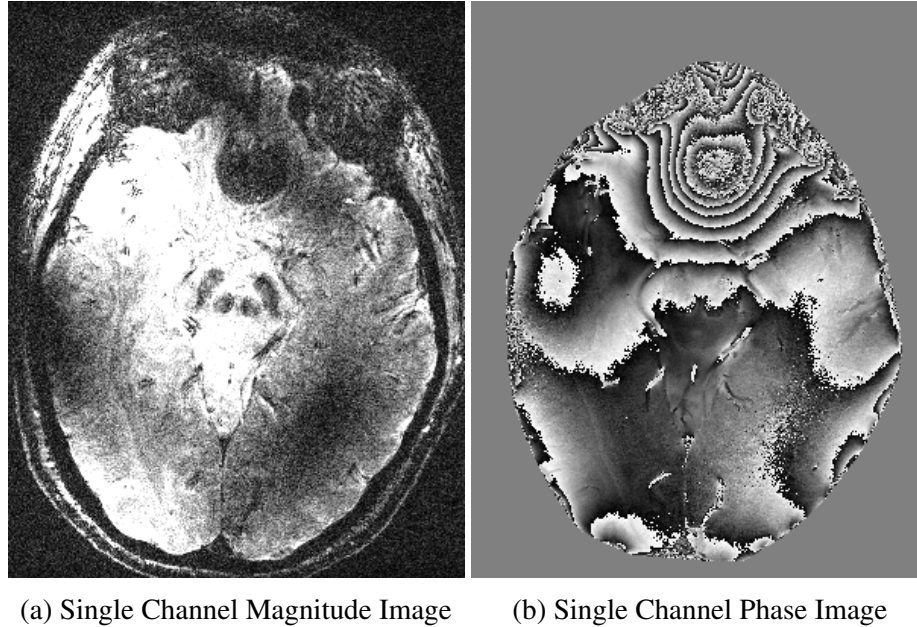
Single channel cranial MR image including magnitude (a) and phase (b) components.
